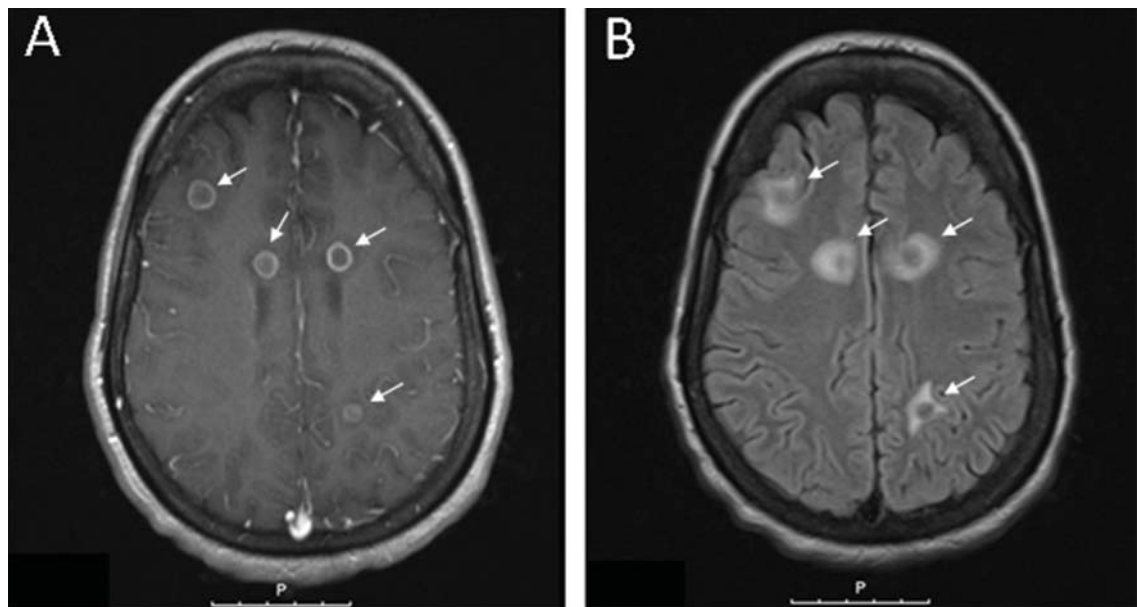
(A) Axial contrast-enhanced T1-weighted magnetic resonance imaging showed ring-enhancing lesions (white arrows), while (B) axial T2-weighted images showed ring-enhancing lesions surrounding hyperintensity, consistent with vasogenic edema (white arrows).
